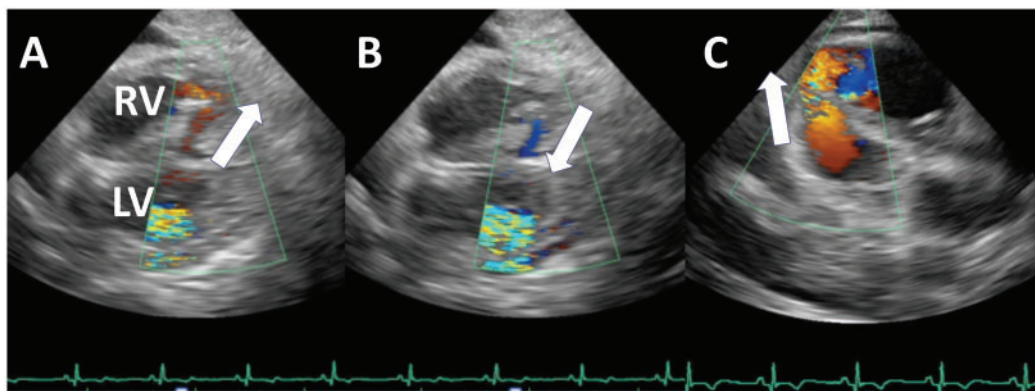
Echocardiogram showed unexpected right-to-left shunt (to-and-fro pattern) via ventricular septal defect (A and B). By increasing extracorporeal membrane oxygenation and decreasing Impella flow, the shunt flow was changed to left-to-right (C). LV, left ventricle; RV, right ventricle.
